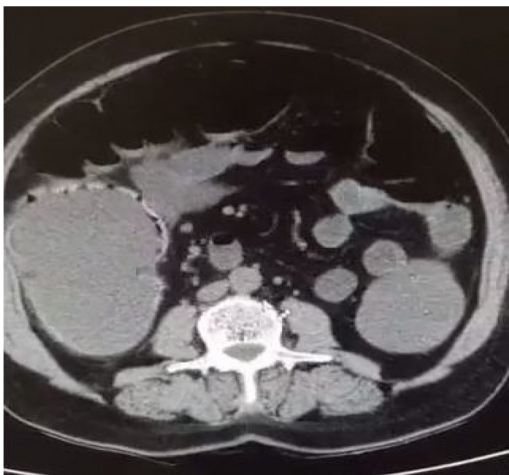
Computed tomography image showing the cecum dilated to 12 cm.
